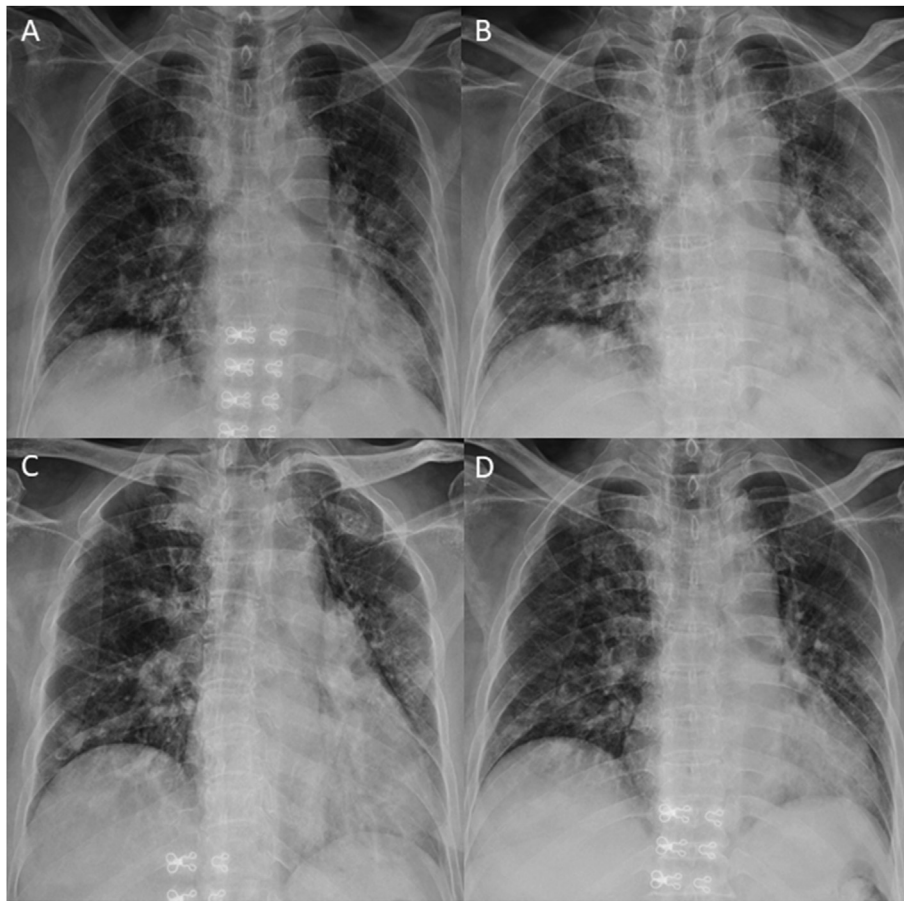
Chest X-rays of a patient with pneumonia on days 1 (A), 5 (B), 10 (C), and 14 (D) after admission.
